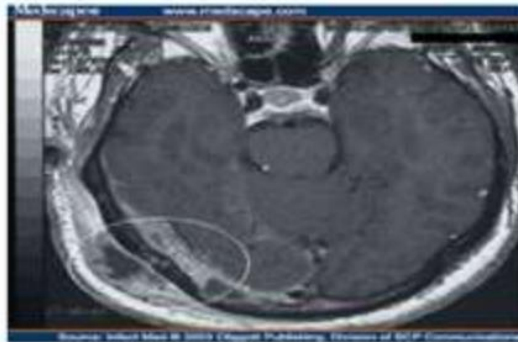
HRCT showing left sided epidural abscess in posterior wall of left petrous bone due to mastoiditis
